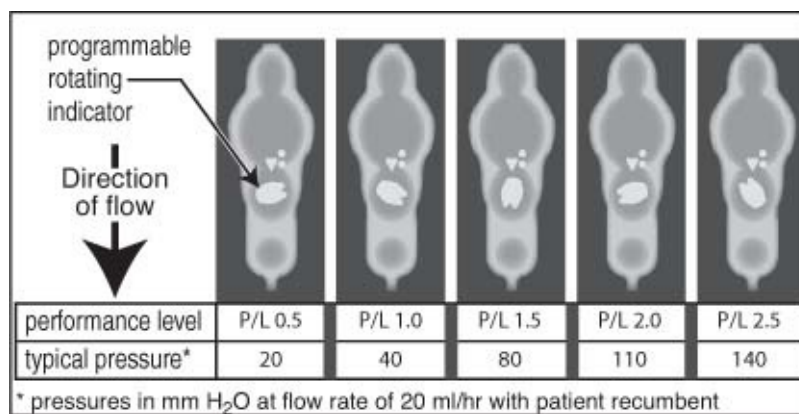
Performance level (P/L) settings for the regular size Strata valve as seen on x-ray
